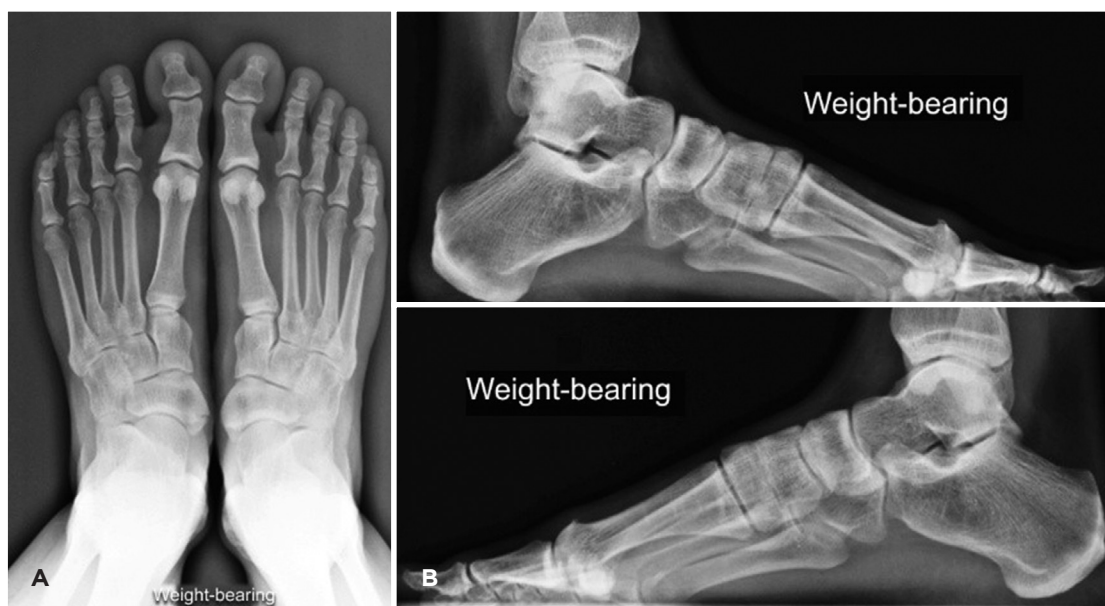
(A) Weight-bearing anteroposterior radiograph of both feet in a patient with Grade 2 hallux rigidus. (B) Weight-bearing lateral radiographs of the right and left feet, respectively.
